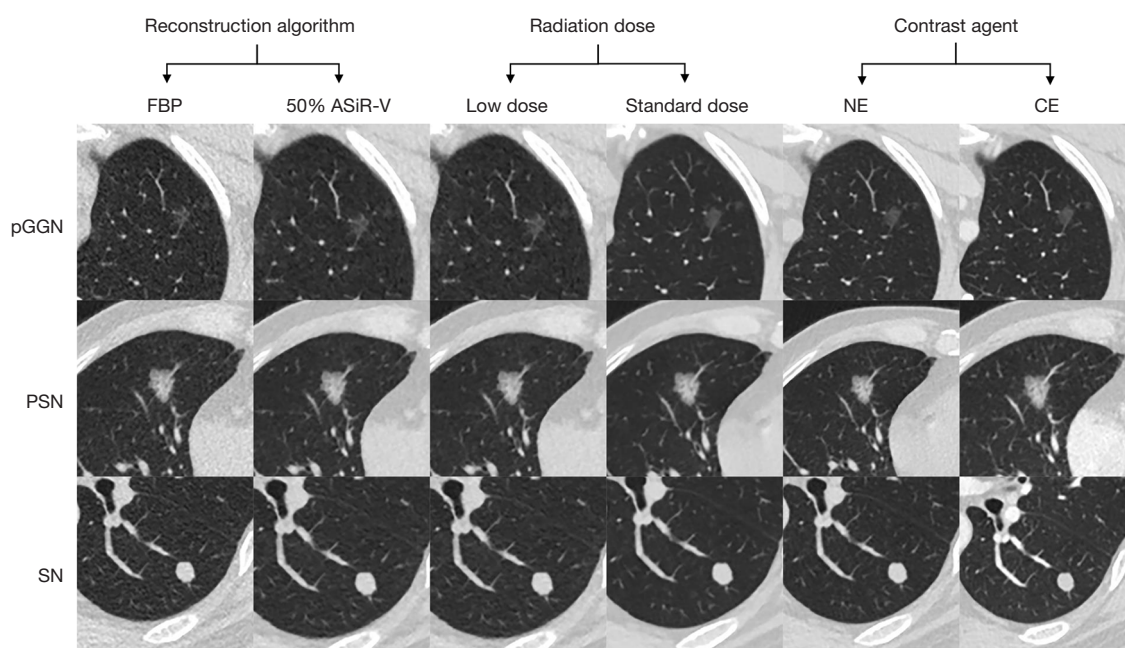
Three pairs of comparison sequences for a pGGN, PSN, and SN. FBP, filtered back projection; ASiR-V, adaptive statistical iterative reconstruction-V; NE, non-contrast enhanced CT; CE, contrast-enhanced CT; pGGN, pure ground-glass nodule; PSN, part-solid nodule; SN, solid nodule; CT, computed tomography.
